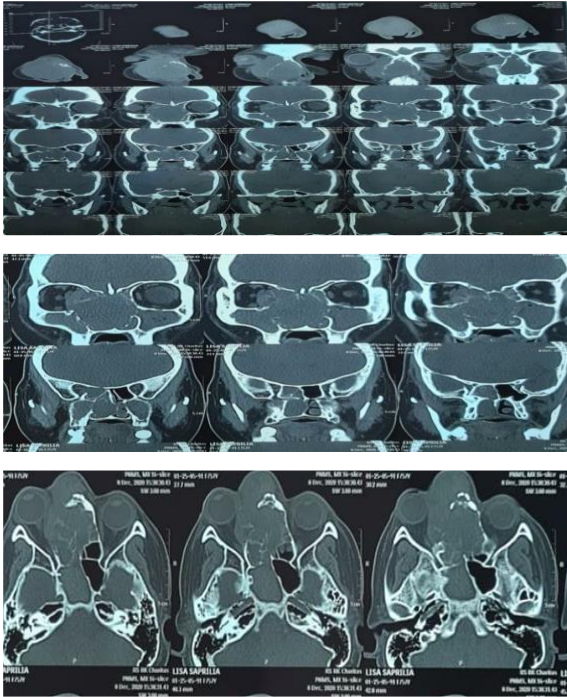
Sinus paranasal CT-Scan showed sinonasal mass from the right maxillary, right ethmoid, right sphenoid and bilateral frontal sinuses.
